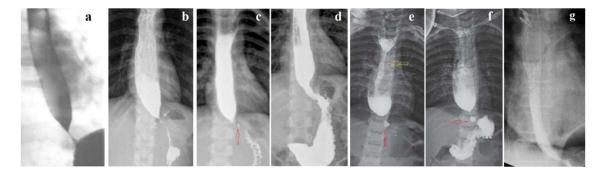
Radiographs of patients with acquired stenosis. (a). An example of the EGL image in GERD. The contracted LES is visible as a thin line between the esophagus and the stomach. The presence of a contrast agent suggests mucosal inflammation of the LES. Conical end of the esophagus authors (b,c,e) call the "bird's beak sign" and on this basis diagnosed EA. (b). A sharply dilated esophagus and a very short distance between the esophagus and the stomach. Arrows indicate a contrast spot in the shortened LES. This is a "trap" of the contrast agent in the inflamed LES, which indicates deformation of the lumen. (c). Before surgery with accumulation of a contrast agent in the shortened LES. (d). The same patient after per oral endoscopic myotomy (POEM). The uneven contours of the gaping LES indicate fibrous deformation of the walls. In another patient, after POEM (g), the contours of the LES are smooth [44]. (e-f). Figure (e) shows the level of fluid in the upper part of the esophagus above the long narrowing (yellow arrow). The second level of fluid in the dilated esophagus is located above the closed LES with a contrast agent trap. Given the long stenosis in the esophagus, there is a high probability that it and the stenosis in the LES are caused by exposure to hydrochloric acid. The child suffered open Heller myotomy and Dor fundoplication [28].
